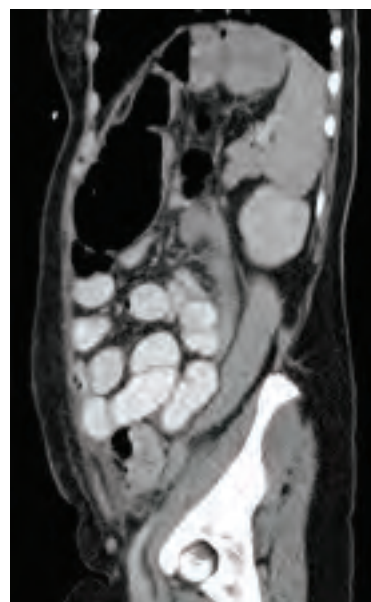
Mechanical large bowel obstruction. CT scan demonstrating a closed loop large bowel obstruction, secondary to extensive leiomyomatous adhesions cicatrizing the rectum and sigmoid.
